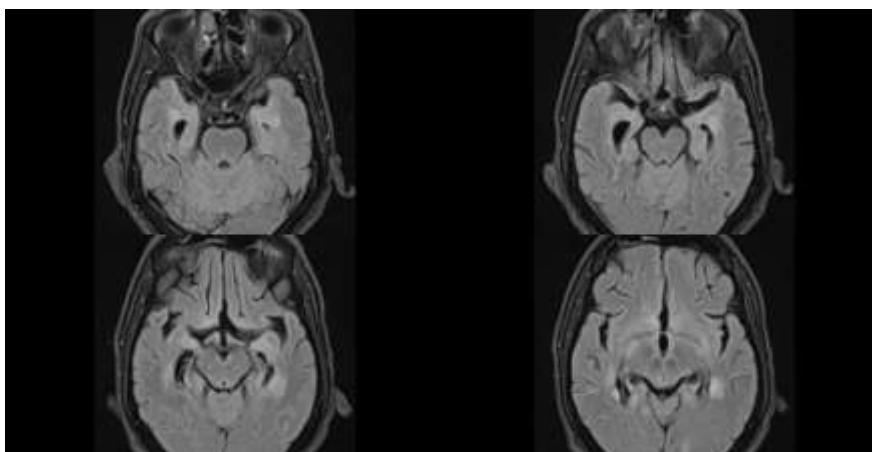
Hippocampal T2-FLAIR hyperintensities
